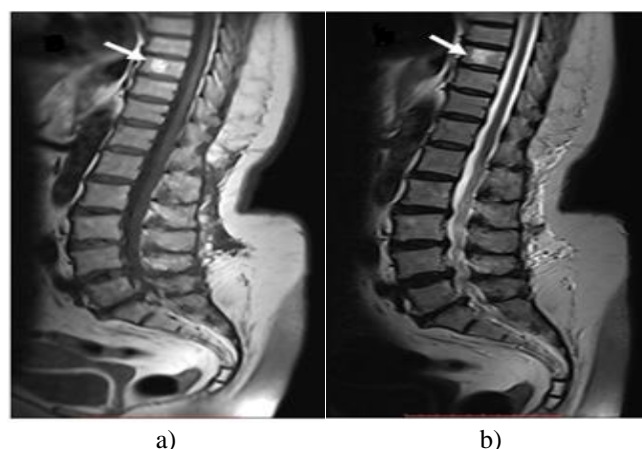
Sagittal T1 and T2- weighted MR images a,b) of the lumbar spine, show a subcentimeter hyperintense lesion on T1. a) and T2-weighted images, b) within the T9 vertebral body (Haemangioma) (arrows).
